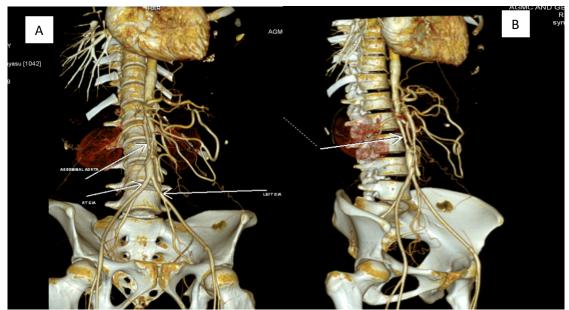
(Abdominal Angiography): 3D CT angiography A & B show- narrowing of abdominal aorta and renal arteries
